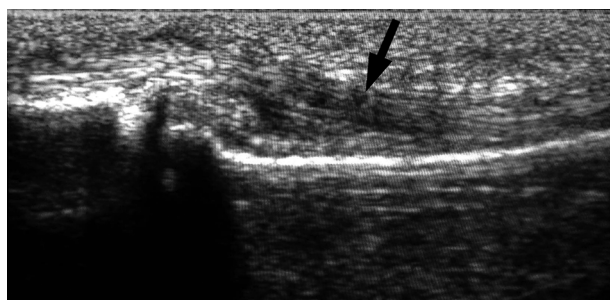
Longitudinal ultrasound image of a flexor tendon reveals an area of focal decrease in tendon echogenicity (arrow) that suggests partial tear
